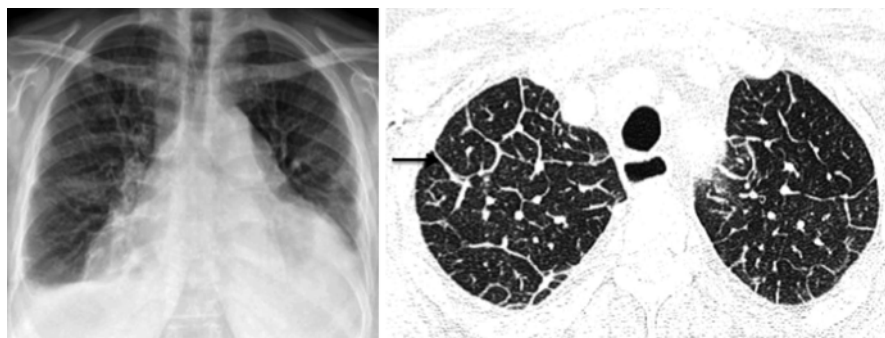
A 49 year-old female patient with progressive breathlessness and history of breast carcinoma. On the CXR, there is enlargement of cardiac silhouette due to pericardial effusion, bilateral pleural effusions, larger on the right and septal thickening, most prominent in the right upper zone due to lymphangitis carcinomatosa. Axial HRCT confirms the upper zone interlobar septal thickening (*black arrow*) in keeping with lymphangitis carcinomatosa
